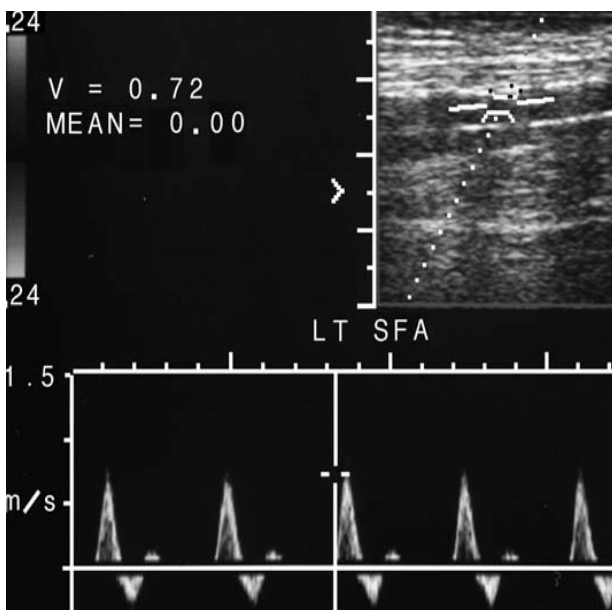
2A Normal superficial femoral artery spectral Doppler waveform
